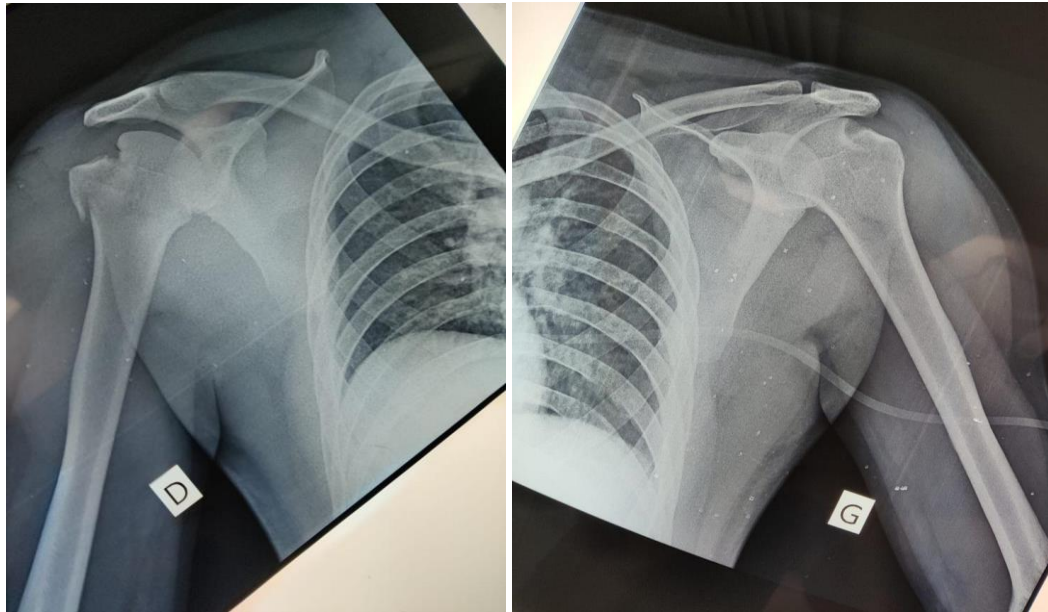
Anterior-posterior radiograph of the shoulders after reduction, showing both humeral heads in place with persistence of the displacement of the greater tuberosity on the right.
